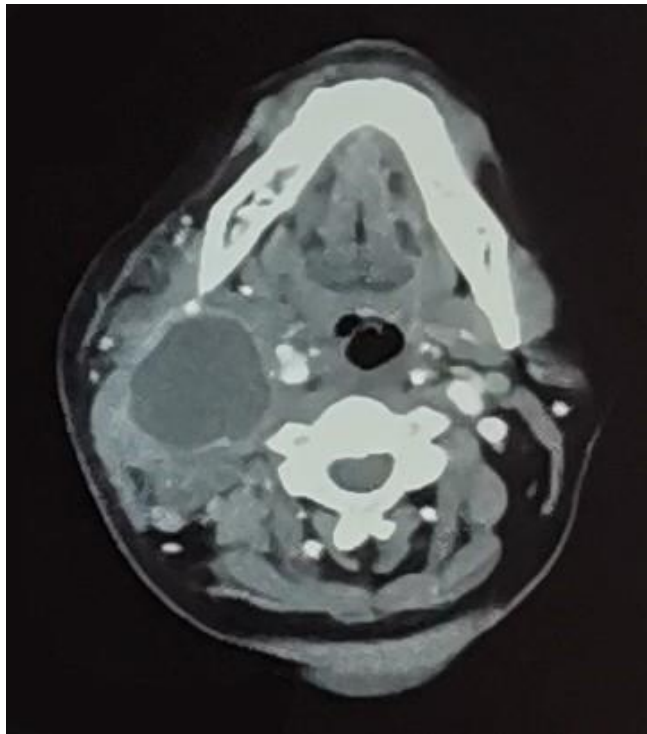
CT of the neck shows a collection within the right carotid space with anterior displacement of the right submandibular gland, right common carotid artery and internal jugular vein
